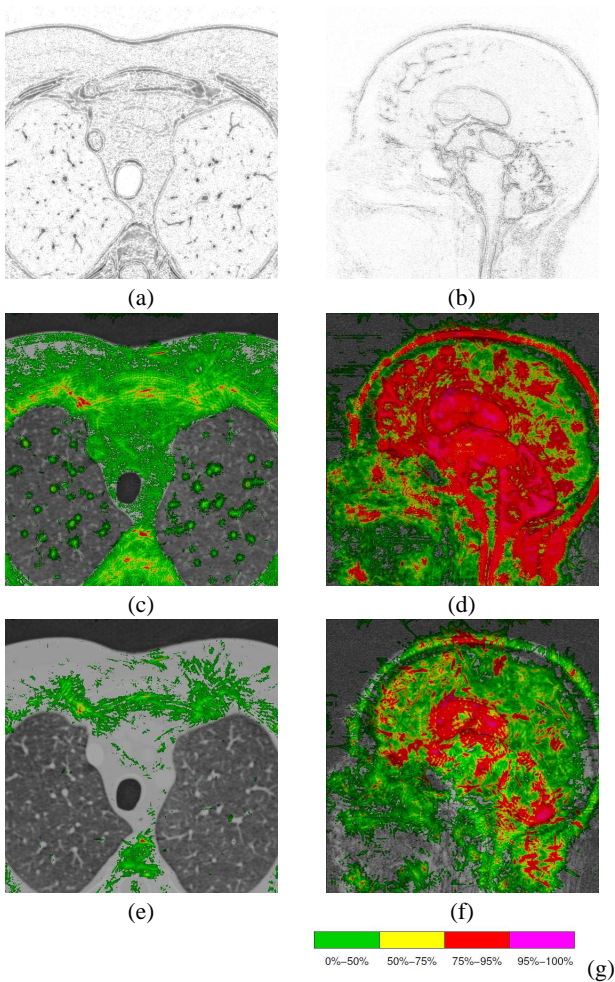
Visual differences between different windowing operators for CT Thorax (a,c,e) and 3D CISS MRI (b,d,f) datasets. The first row shows the relative intensity between zone intensity mapping and VHDR windowing (images are darkened for printing contrast). The other rows show a perceived intensity difference between zone intensity mapping and VHDR windowing (2nd row), and between slice-based HDR and VHDR windowing (3rd row) based on a Visual Difference Predictor [15]. (g) shows its color-coded scale of the detection probability.
